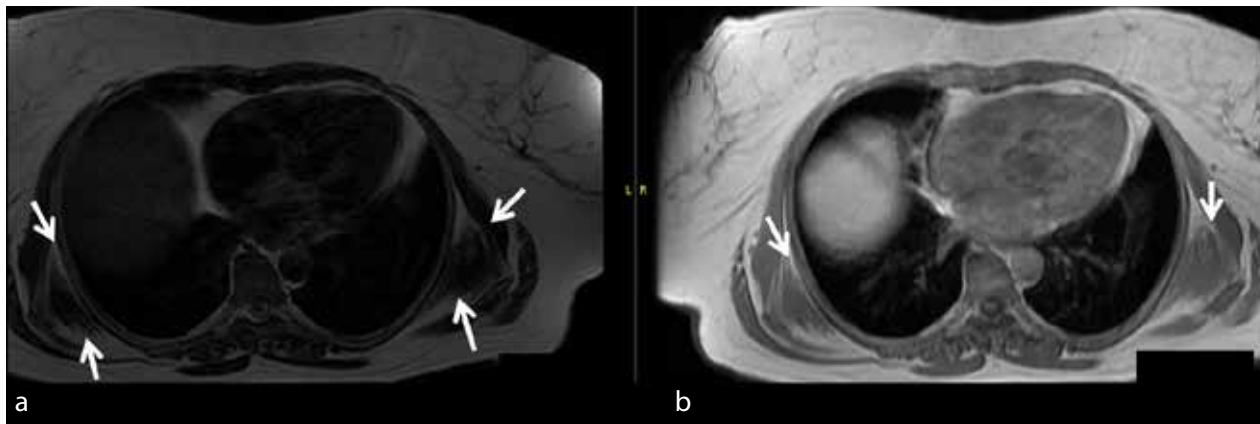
a, b. Magnetic resonance imaging: T2-weighted (a) and T1-weighted (b) images on axial plane show lesions (arrows) that have the same intensity as the muscle tissue and are consistent with elastofibroma.
